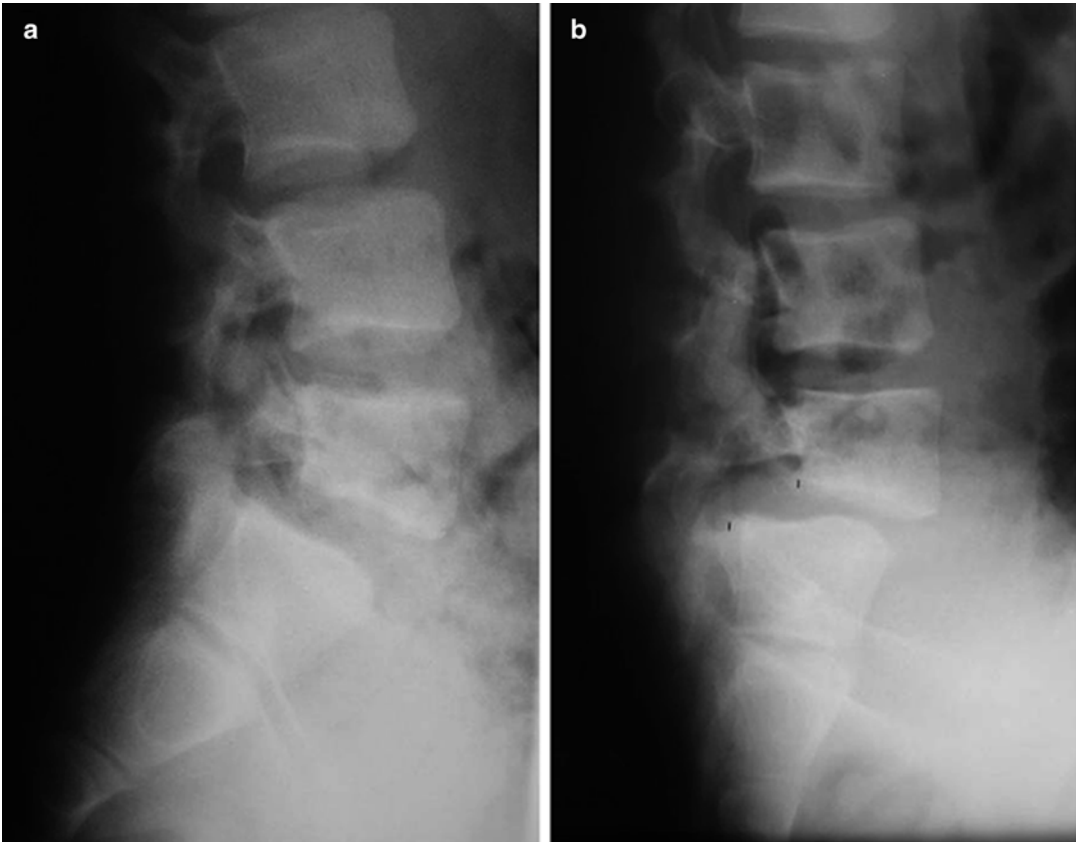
(a, b) Case 1: 20-year-old female with an isthmic spondylolisthesis at L5–S1 refractory to non-operative treatment. Presents with low back pain and bilateral L5 radiculopathy. Lateral neutral and flexion radiographs showing Grade 2 slip
